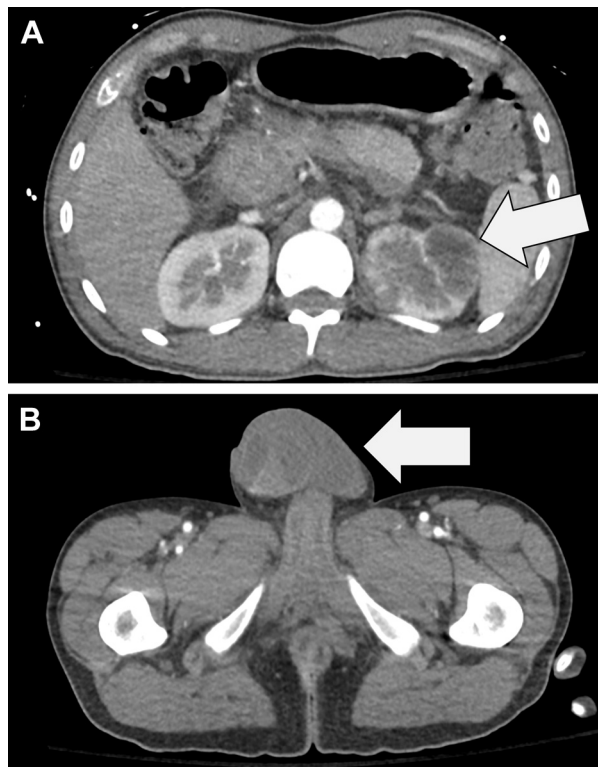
Noncontrast CT scan of the abdomen and pelvis demonstrating (A) a 3 × 3 cm hypodense lesion in the left kidney; and (B) a 5 × 5 cm mass-like lesion in the right testicle (white arrows).
